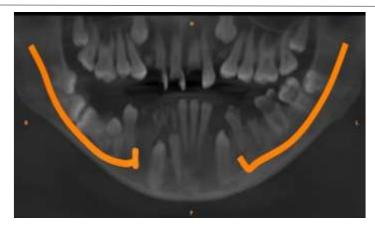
Reconstructed panoramic image of CBCT showing impacted and retained teeth
